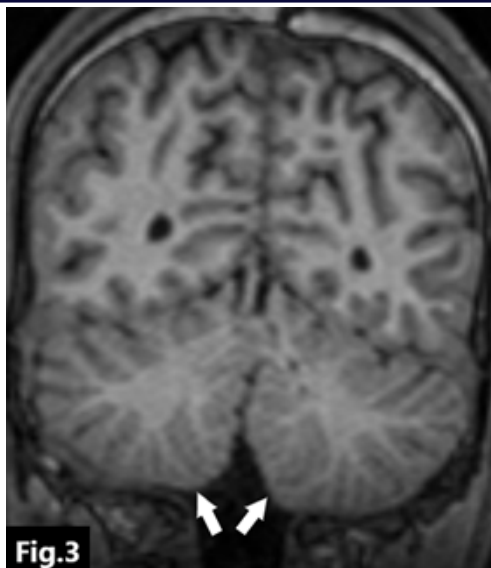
MRI T1 WI coronal section showing the cerebellar hemispheres (white arrows) are in close approximation in the midline separated by a sagittal cleft due to agenesis of the cerebellar vermis giving the 'Buttock Sign'.
